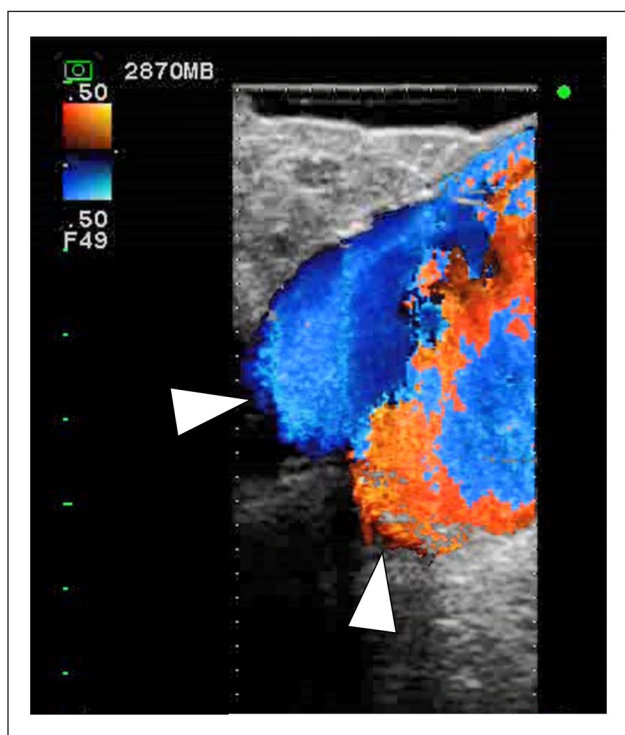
Epi-aortic echocardiography during reversed perfusion (directing the aortic cannula toward the aortic root) reveals that the reversed blood flow turns around at the position of the aortic valve (arrowheads) and does not flow to the left ventricle.
